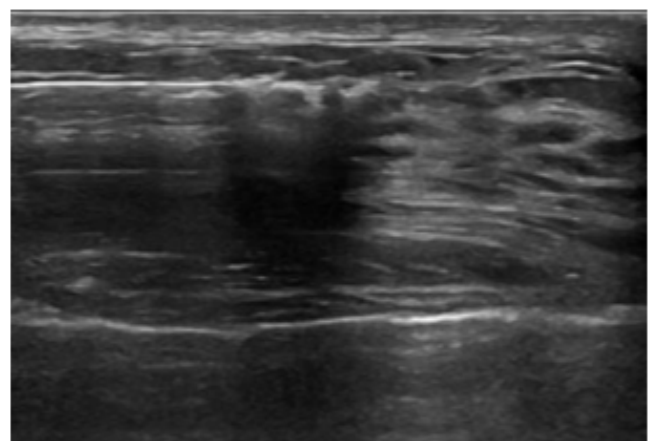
Breast ultrasound was performed at another institution.
